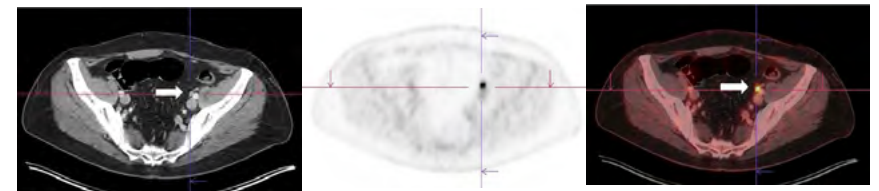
[¹⁸F]FDG PET/diagnostic contrast-enhanced CT in a patient with a diffuse large cell B lymphoma – focally increased metabolic activity (SUV max 9.7) in a less than 0.5 cm lymph node just adjacent to the left external iliac vessels (arrows), which could not have been clearly delineated by a »low-dose« PET/CT scan.
